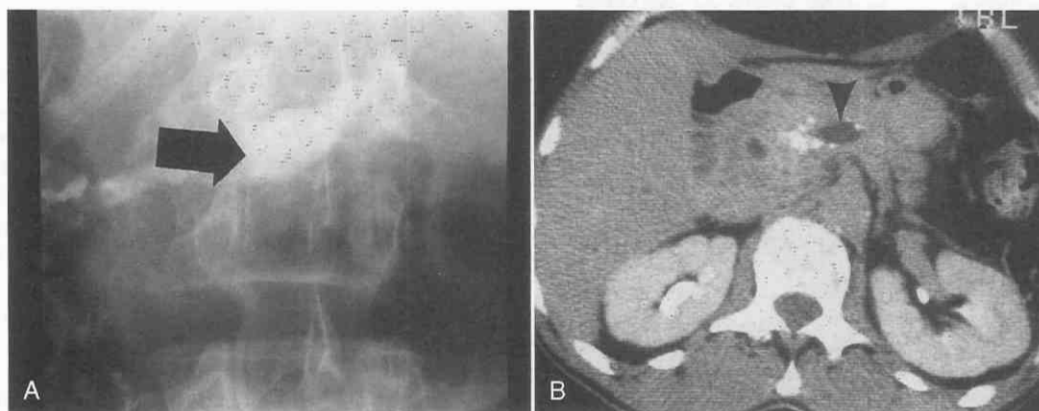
A, Pancreatogram shows diffuse dilatation with a central ectasi (*arrow*). B, CT scan shows central dilatation of the main pancreatic duct, resulting in a small retention cyst (*arrowhead*).
